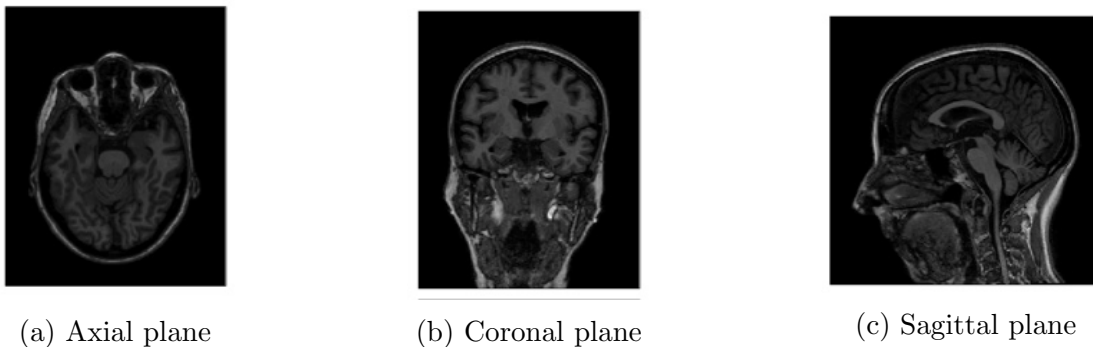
Two dimensional orthogonal projection of MRI images before preprocessed.
